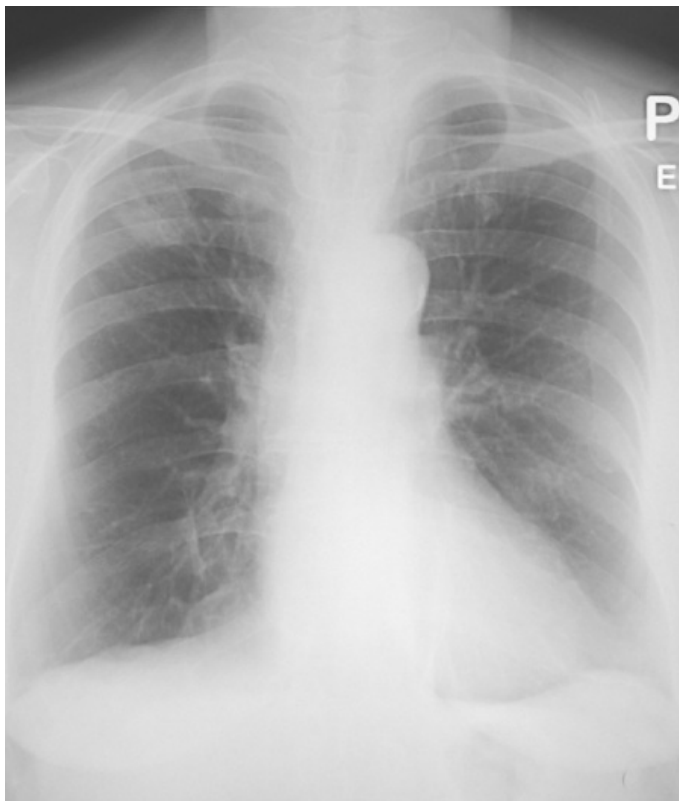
Chest x-ray of a bronchial carcinoma
